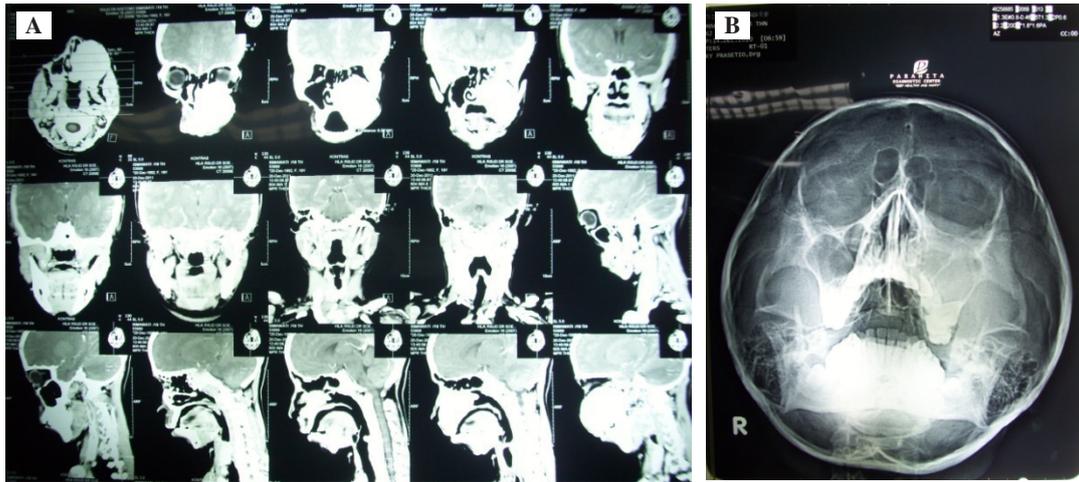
Preoperative CT Scan and Water's radiographic view. CT scan showed a solid mass in the left sinus maxillary with calcified components inside and nasal septal deviation to the right (A). Water's radiographic showed radiopaque area in left maxilla (B).
